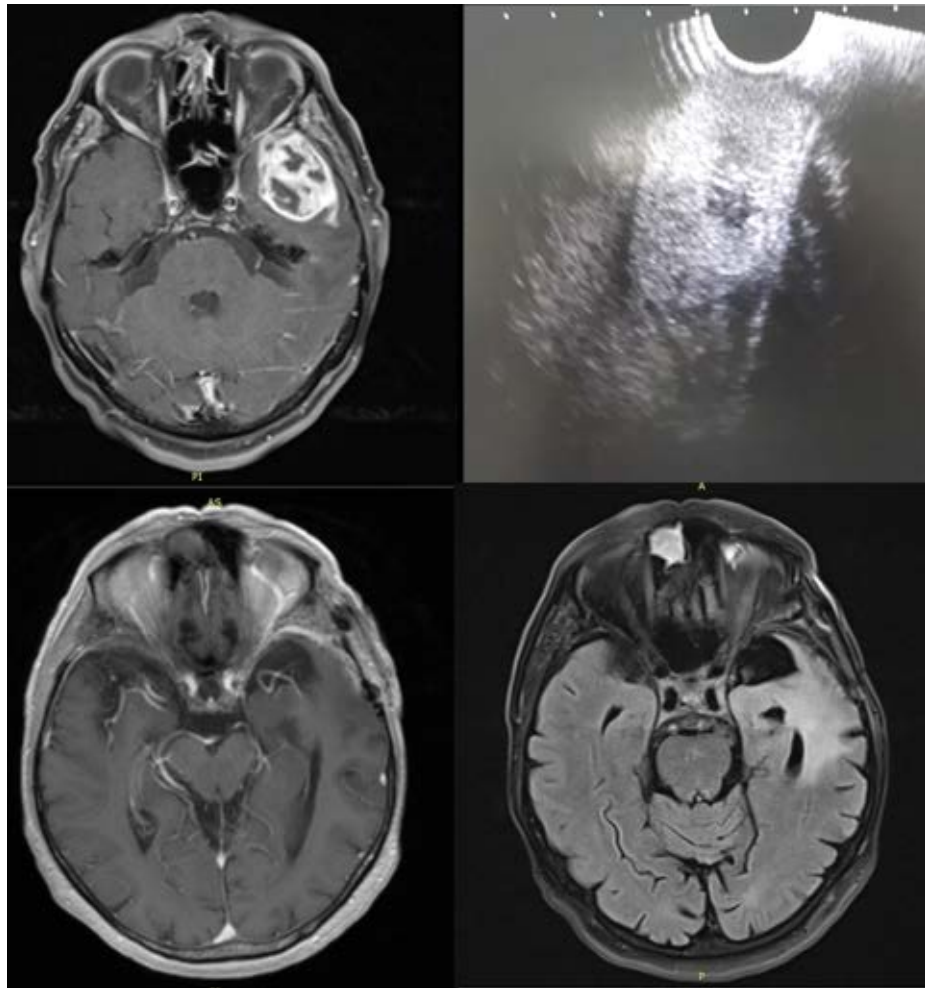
Frontal lobe glioblastoma (Grade IV): (A) preoperative MRI, (B) IOUS before resection, (C) postoperative MRI, and (D) post-radiation MRI.
